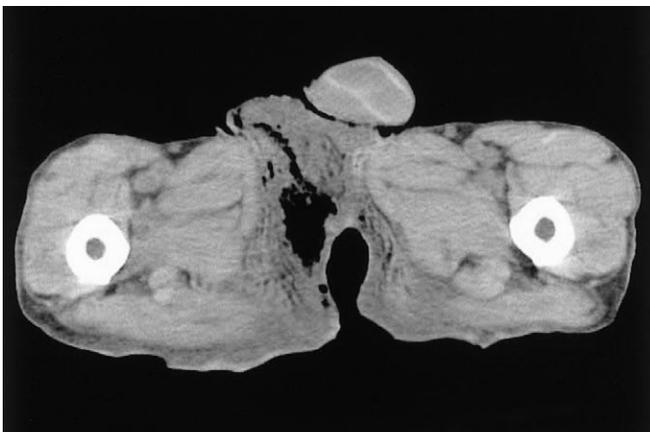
Case 2. Pelvic computed tomography revealed a gas shadow that had spread to the subcutaneous space of the right-sided perineum and the scrotum.
